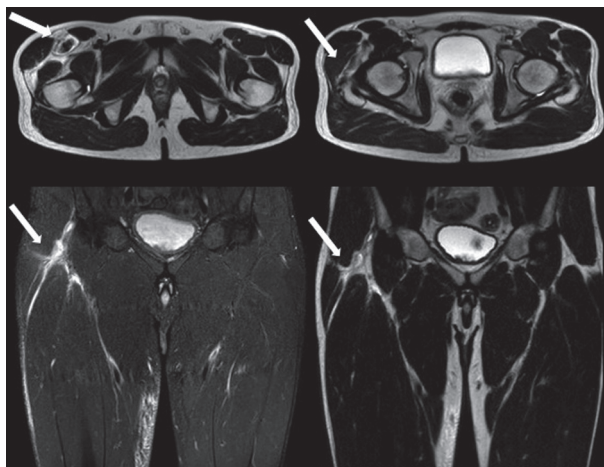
MRI performed 6 days after injury with the signs of myotendinous lesion and retraction (arrows); coronal and axial views
